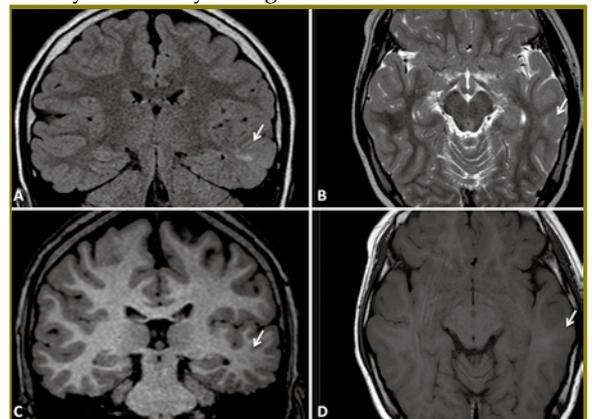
MRI of a patient with FCD over left middle temporal gyrus (arrows). A: FLAIR sequence. B: T2-weighted sequence. C and D: T1-weighted sequences. Source: From personal collection.
